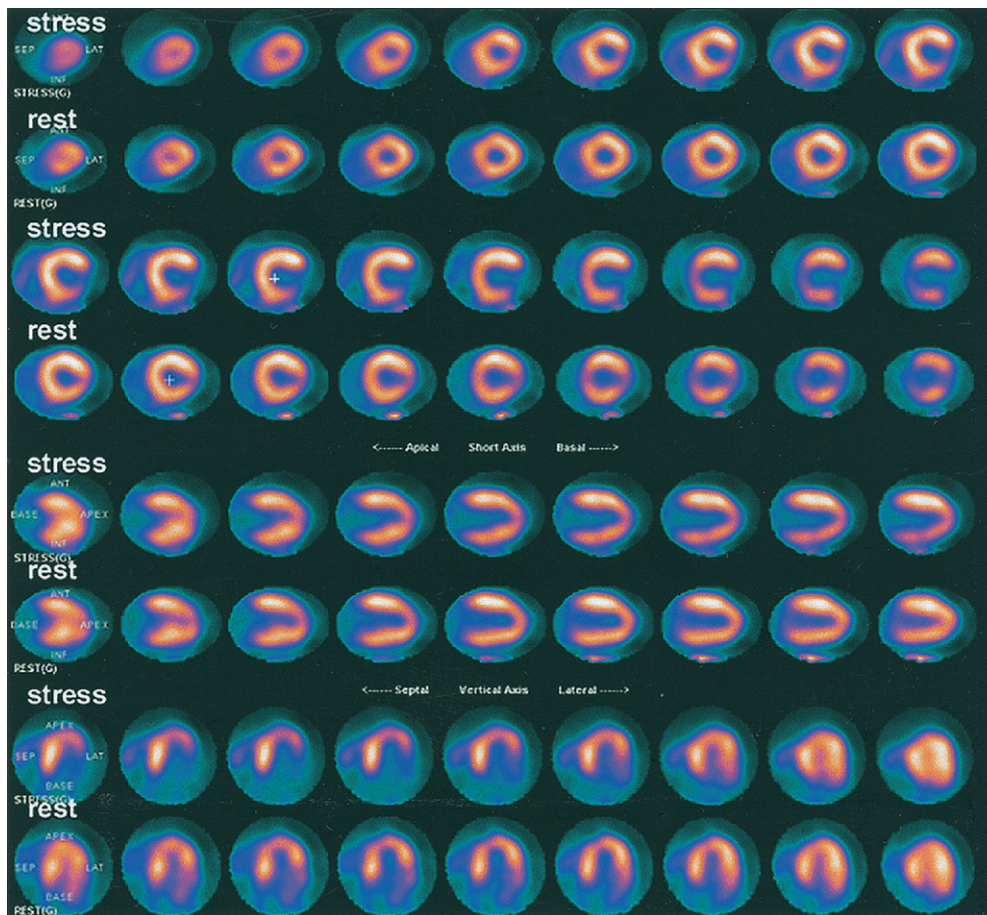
Abnormal Rubidium-82 Myocardial Perfusion PET-CT Study
